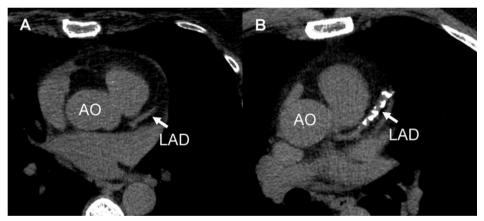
Example of coronary calcium on non-contrast enhanced multislice computed tomography (MSCT) axial images. Calcifications appear as bright white dense structures on MSCT. Panel A shows a 57 year old patient without evidence of coronary calcifications in the left anterior descending coronary artery (LAD). Panel B shows a 53 year old patient with calcifications in the LAD. AO - Aorta.
